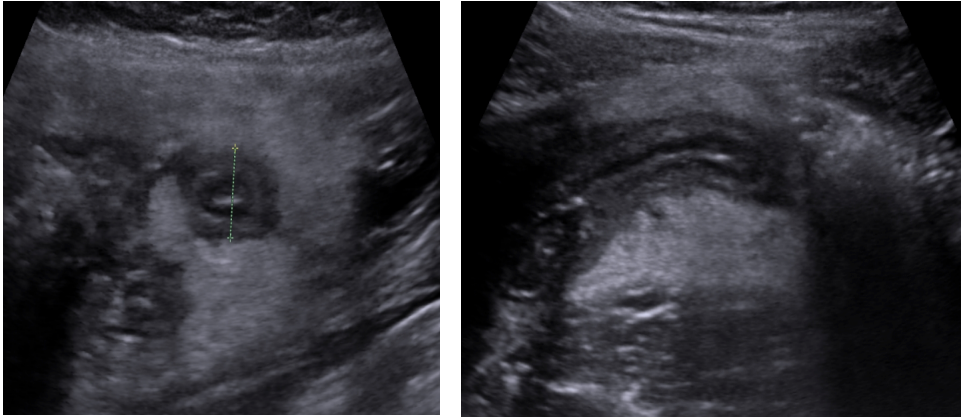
Ultrasound showing acute appendicitis
